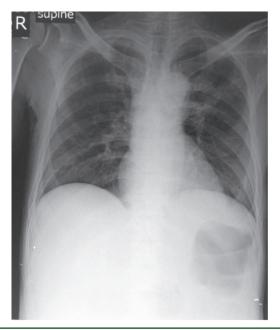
Chest X-ray of case 2 (pre-treatment of tuberculosis) showed left upper lung infiltration.
